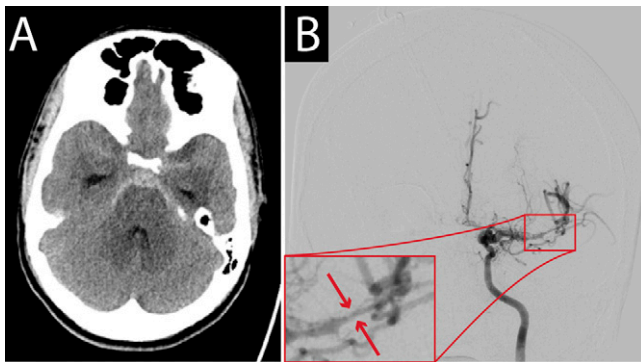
Initial CT revealing spontaneous SAH. A: CT of the head on presentation showing SAH in the basal cisterns. B: Catheter cerebral angiogram showing severe vasospasm (red arrows).
